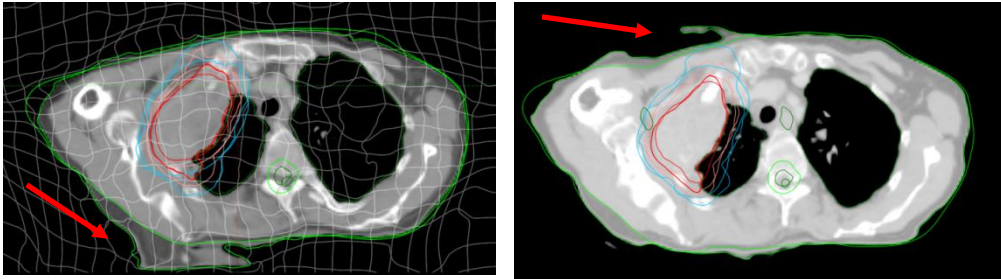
Two examples of erroneous CBCT image registrations (red arrows) due to image artifacts in the registered images (not presented, see example in Paper I, Chapter 8). The DVF is presented as light gray lines in the left figure.
